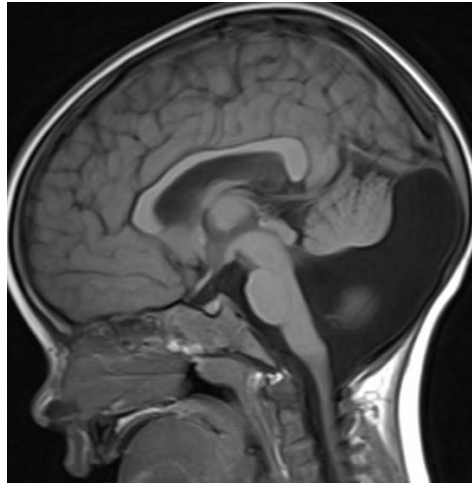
Same patient on sagittal. T2 weighted MRI shows vermian hypoplasia with upturned vermis, increased tegmo-vermian angle elevated torcula and enlarged posterior suggestive of dandy walker malformation
